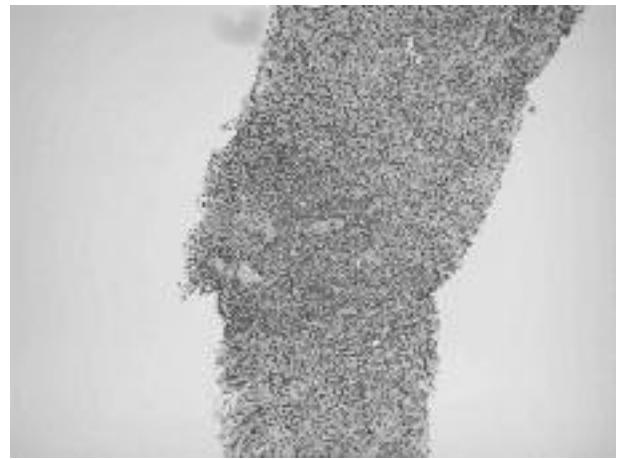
Case 2. CT-guided fine-needle sampling of the peri-hepatic lesion: diagnosis was again Castleman's Disease
